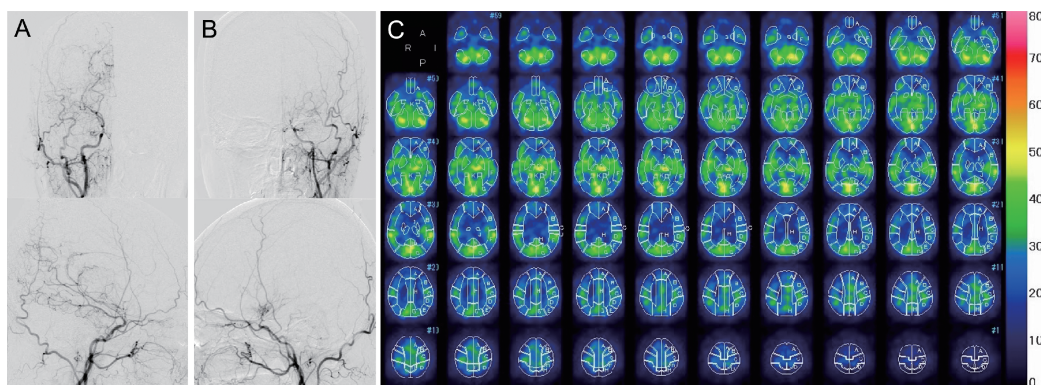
Preoperative cerebral angiography (A, B) and N-isopropyl-p-[¹²³I]-iodoamphetamine single photon emission computed tomography (¹²³I-IMP SPECT) imaging (C)
